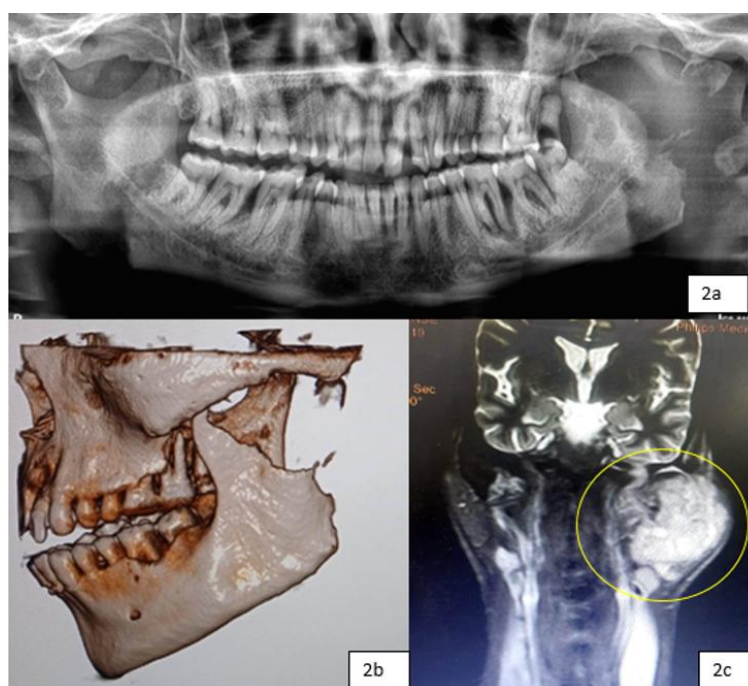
OPG showing osteolytic lesion on left ramus, FIG 2b: 3d reconstructed view of CBCT, FIG 2c : MRI involving intracranial component
